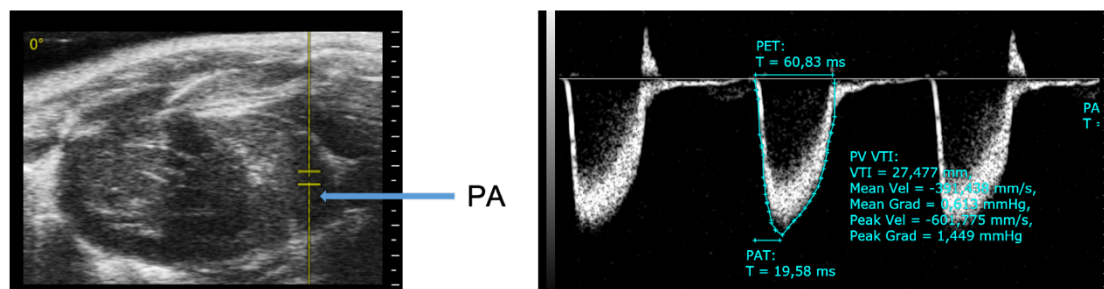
The view of modified Parasternal Long Axis(mPLAX) and measurements of pulmonary artery accelerating time(PAAT) and pulmonary ejection time(PET).
